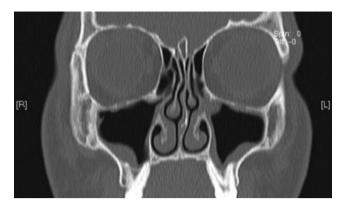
CT scan: A typical CT scan of a patient with early stage CRSsNP, showing some opacification of the OMC-area and the maxillary sinuses.
